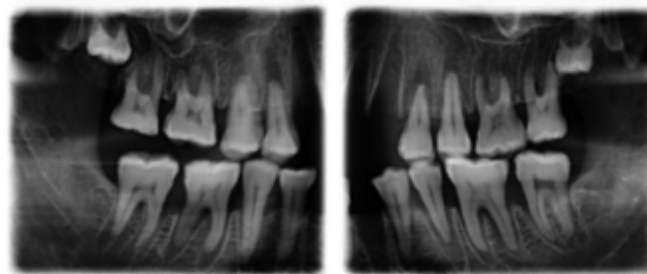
The image of extraoral bitewing (El-Ela et al., 2016)
